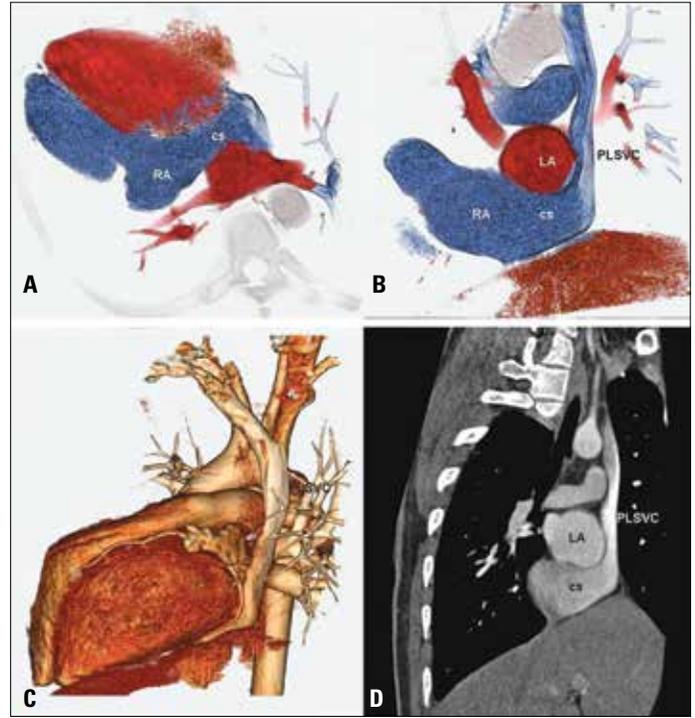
Colored subvolume (A, B), colored three-dimensional volume rendered (C) and oblique sagittal MPR CT images (D) of PLSVC and dilated CS
